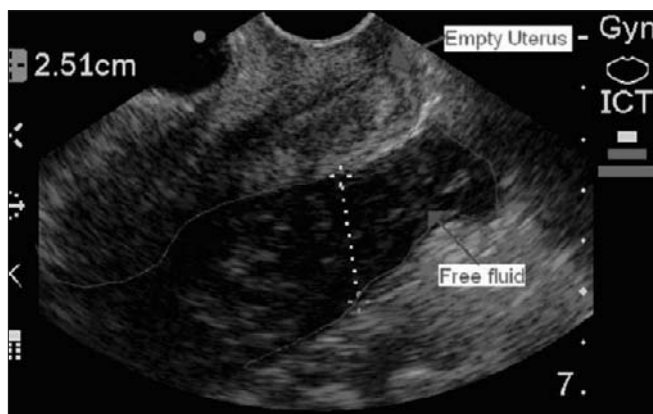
Results of 2nd emergency bedside ultrasonography, performed at 3rd visit, after patient arrived by ambulance, show a large volume of free fluid in the pouch of Douglas. As in the first emergency bedside ultrasound, no intrauterine gestation was seen on the endovaginal scan.
